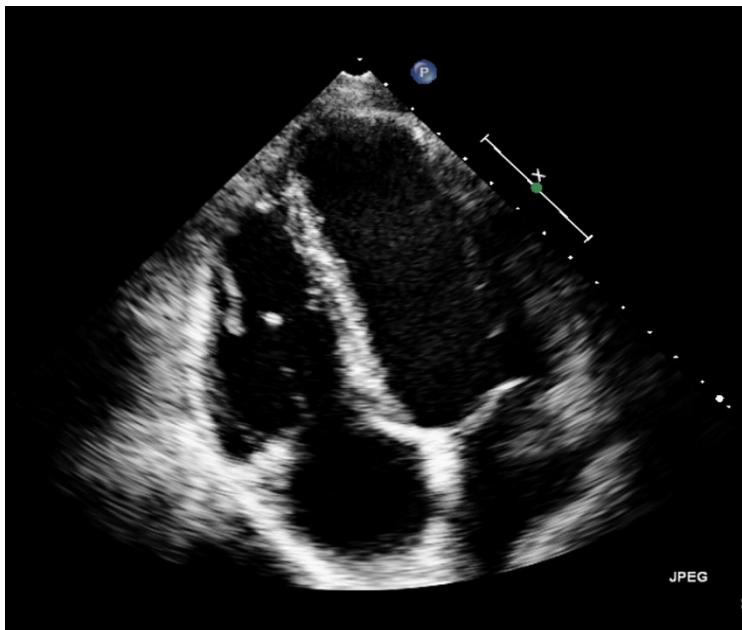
Tilted apical four chamber view with right ventricular focus.
